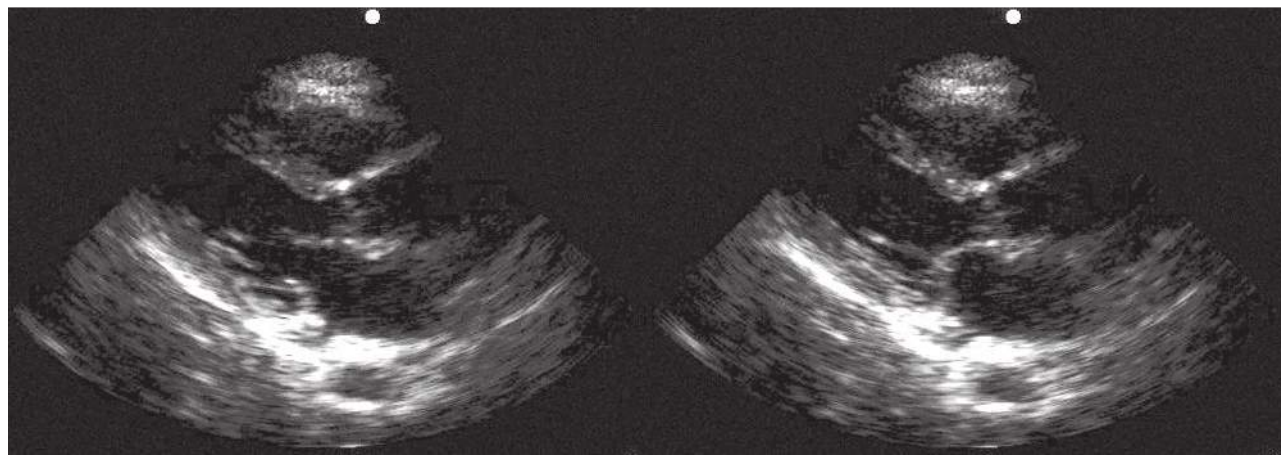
Parasternal long-axis view, depressed ejection fraction. Parasternal long-axis view during (a) diastole and (b) systole, demonstrating moderately reduced ventricular function. Note the incomplete excursion of the anterior mitral valve leaflet during diastole, < 40% reduction in left ventricular diameter during systole, and poor ventricular wall thickening during systole.
